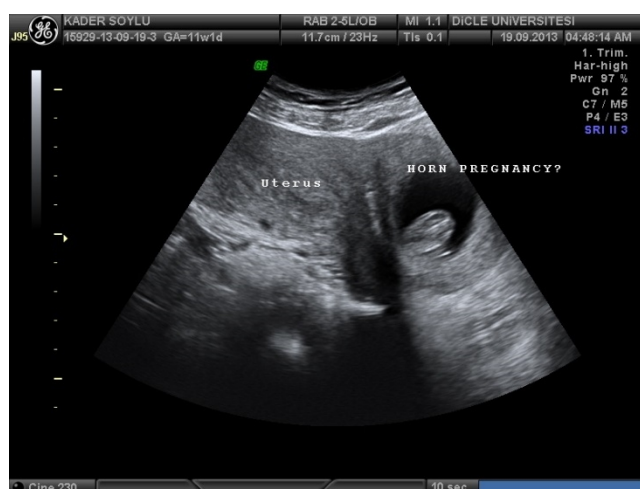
Ultrasonographic presentation of the second case. Gestational sac with thick myometrium observed on the right.
